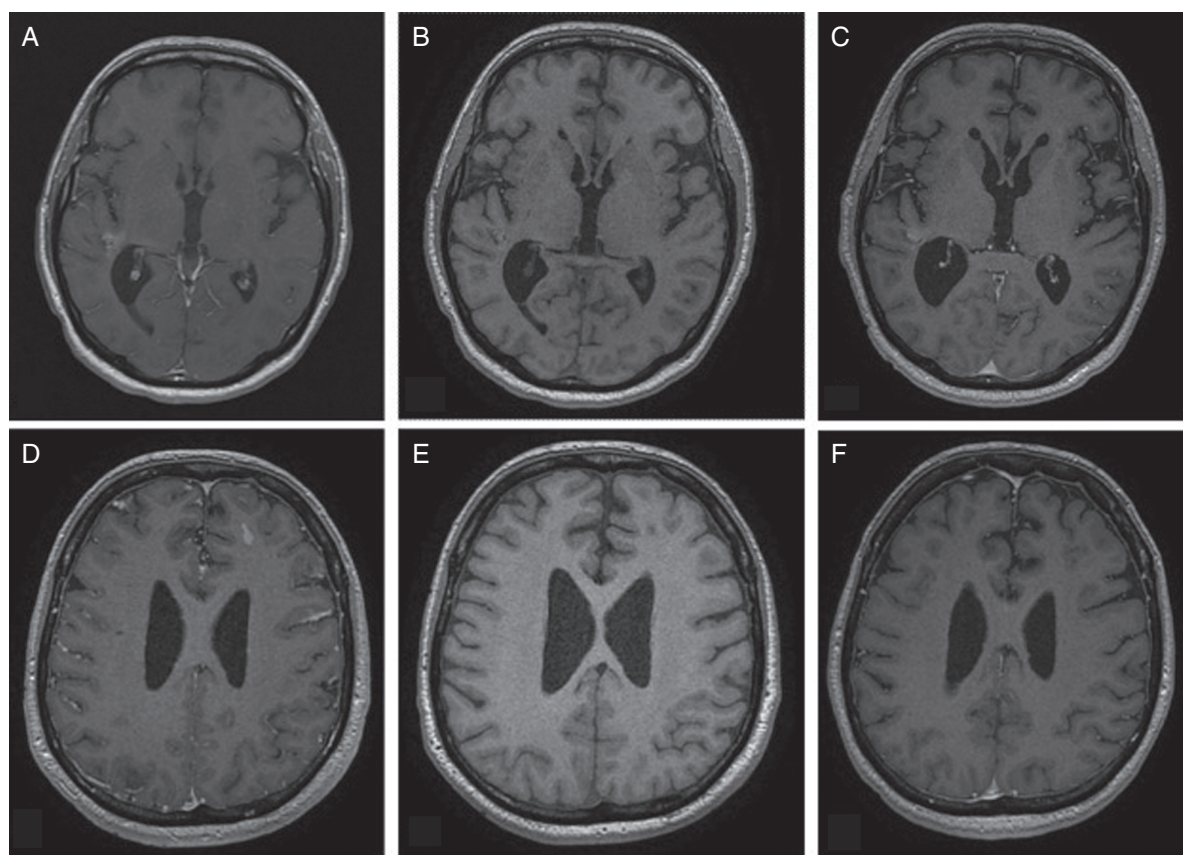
MRI brain showing first intracranial recurrence and subsequent radiographic remission. (a) T1 post-contrast with right temporal enhancement. (b) T1 pre-contrast for comparison. (c) T1 post-contrast following treatment with attenuation of right temporal enhancement. (d) T1 post-contrast with left frontal parenchymal and leptomeningeal enhancement. (e) T1 pre-contrast for comparison. (f) T1 post-contrast with a resolution of left frontal parenchymal and leptomeningeal enhancement.
